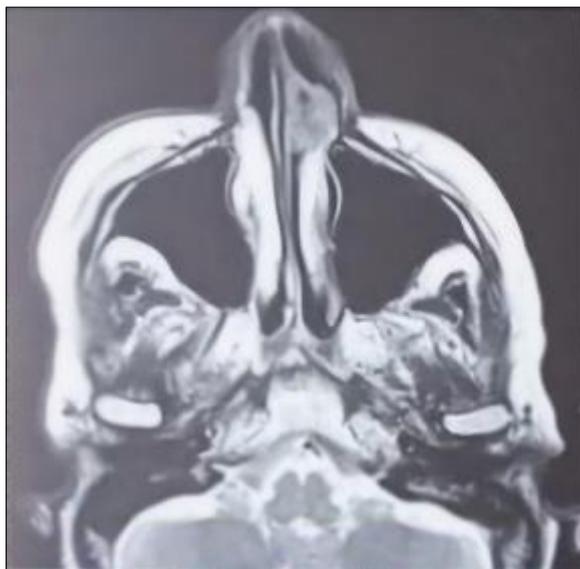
MRI showing the left nasal cavity mass
